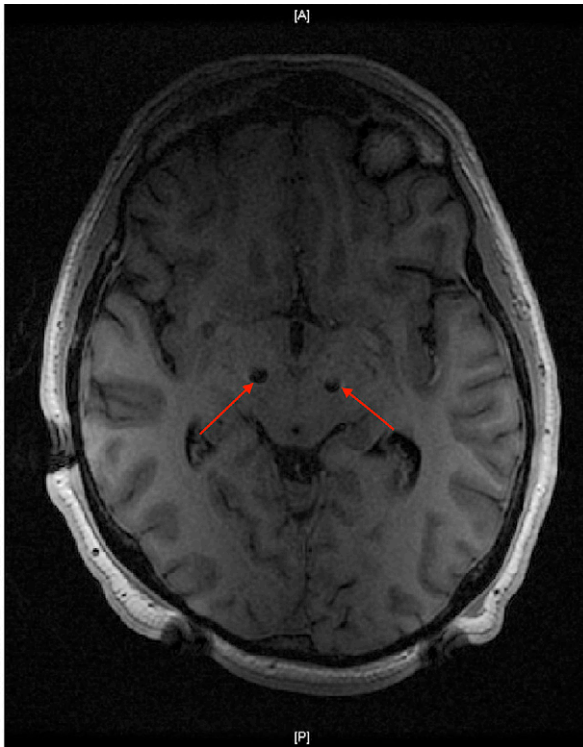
Intraoperative MRI scan shows DBS lead placement (*red arrows*) at the level of the target.
